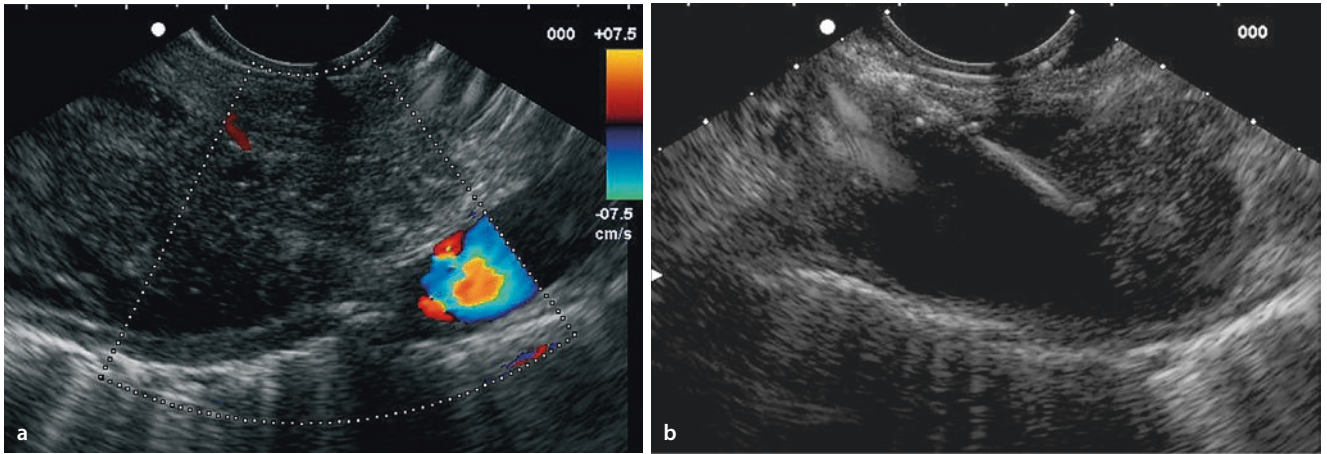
Paravertebral abscess in a case of spondylodiscitis. At first, open surgical drainage of the spondylodiscitis was performed, followed by endosonographically guided nasal/transesophageal
